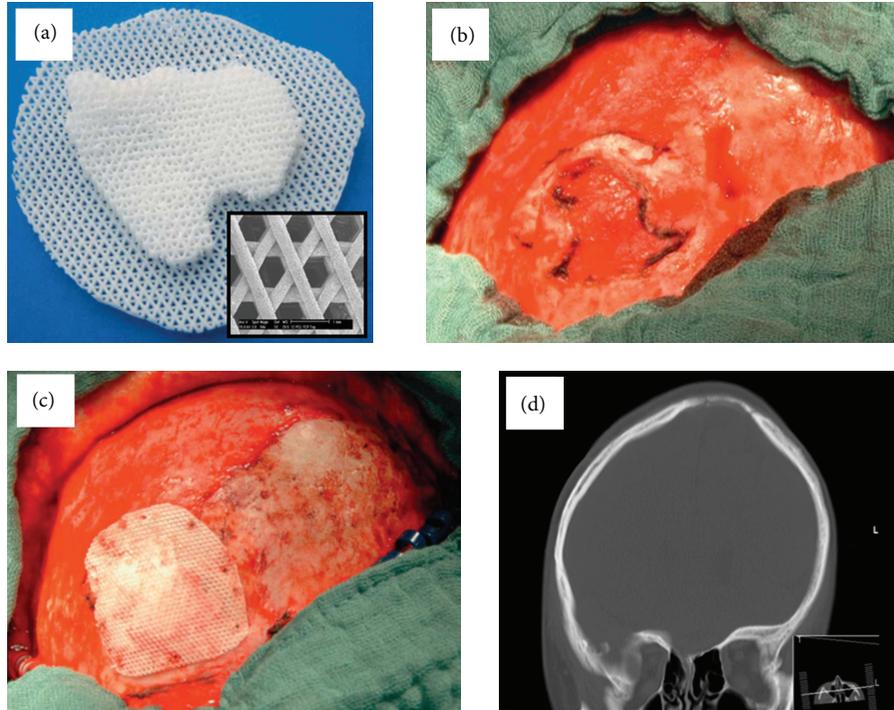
Clinical application of a cell-free polycaprolactone-calcium phosphate scaffold for bone regeneration in a calvarial defect. Scaffold designed using CT imaging data and fabricated by fused deposition modeling (a). Calvarial defect (b). Defect after implantation of the scaffold (c). CT images showing bony consolidation of the defect after 6 months (d). Reproduced with permission from Georg Thieme Verlag (2012) [3].
